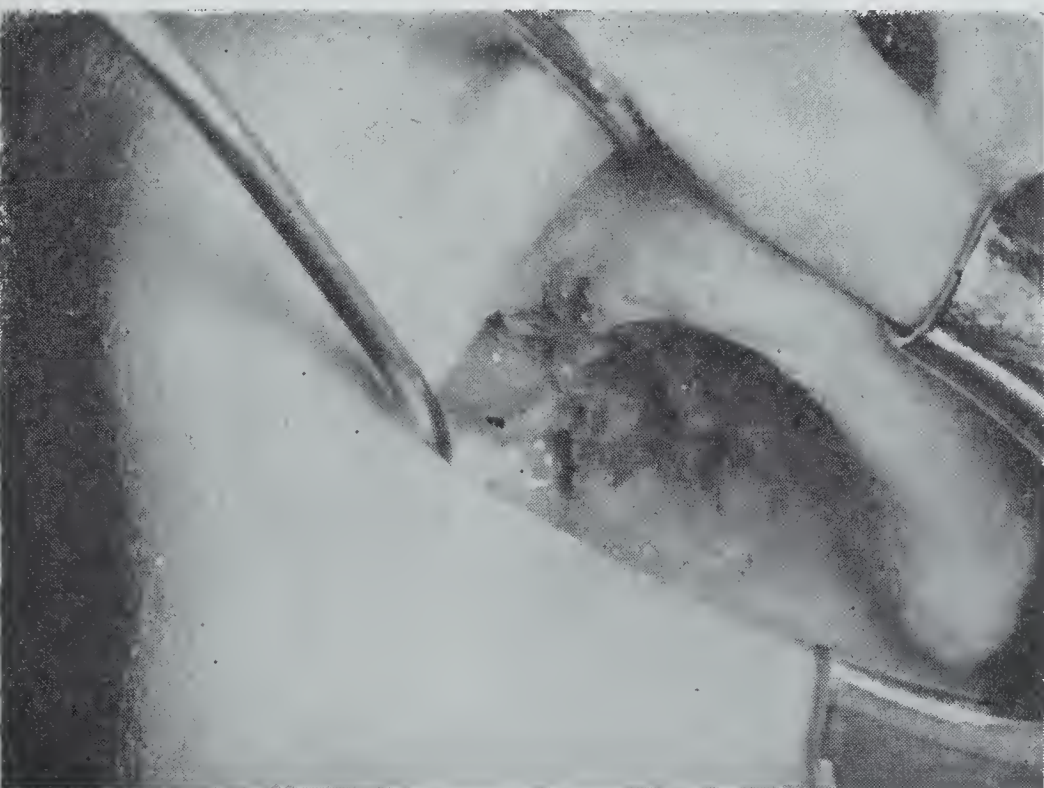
An extensive squamous cell carcinoma involving the right half of the soft palate and extending onto the right upper gingiva which was treated with intraoral roentgen therapy, 4000 roentgens administered through an intraoral cone. Four weeks later, resection of the right superior maxilla was carried out.
